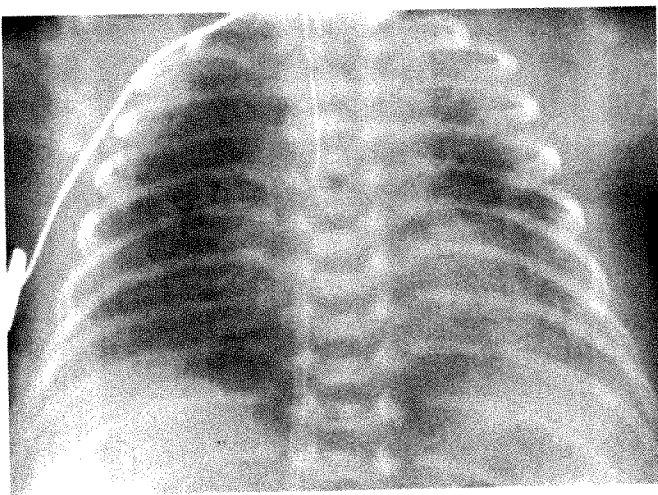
A-C, Chest radiographs in three infants show central clearing and residual peripheral atelectasis at 4 hr (A), 5 hr (B), and 8 hr (C) after surfactant administration.
